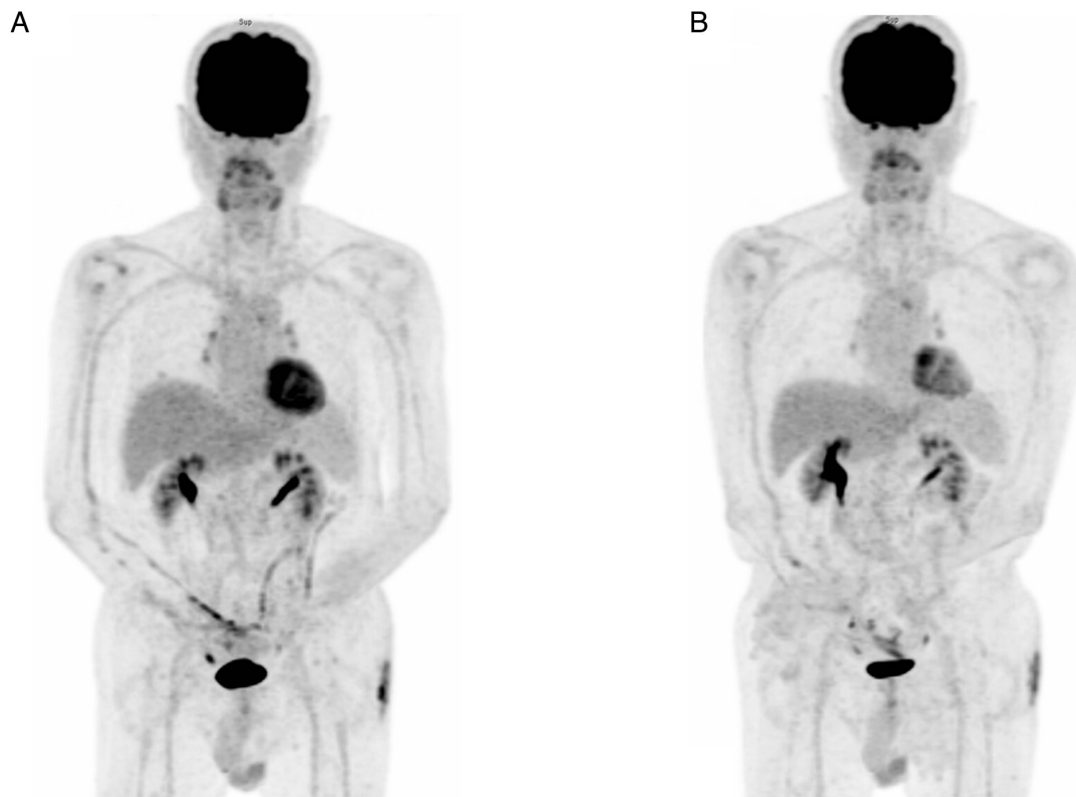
Follow-up PET scans. (A) PET scan in January 2024 (about two years and three months after the first encounter). Relatively stable appearance of the previously noted FDG-avid lesions over the mediastinum (e.g. AP window LN, SUVmax: 4.1), RLL lung (SUVmax: 2.5) and cutaneous region of the left buttock (SUVmax: 7.2), suggesting lymphoma (probably mixed with inflammation) under treatment in a relatively stable disease condition (SD; Deauville score, 4). Furthermore, normal physiological FDG accumulation in the cerebral cortex, adenoids of tonsils, vocal cords, heart, aorta, T-L spines, renal pelves, ureters and bladder was seen. (B) PET scan in September 2024 (about two years and eleven months later after first encounter). The study showed a relatively stable appearance of the previously noted FDG-avid lesions over the mediastinum (e.g. AP LN, SUVmax: 3.8; previously 4.1), RLL lung (SUVmax: 1.6; previously 2.5) and cutaneous region of the left buttock (SUVmax: 4.8; previously 7.2), suggesting lymphoma (probably mixed with inflammation) post-treatment in a relatively stable disease condition (SD; Deauville score, 3-4). Furthermore, normal physiological FDG accumulation in the cerebral cortex, adenoids of tonsils, vocal cords, heart, aorta, T-L spines, renal pelves, ureters and bladder was seen. PET, positron emission tomography; FDG, 18-fluorodeoxyglucose; RLL, right lower lobe; SD, stable disease; AP window, aortopulmonary window; LN, lymph node; SUVmax, maximal standardized uptake value.
